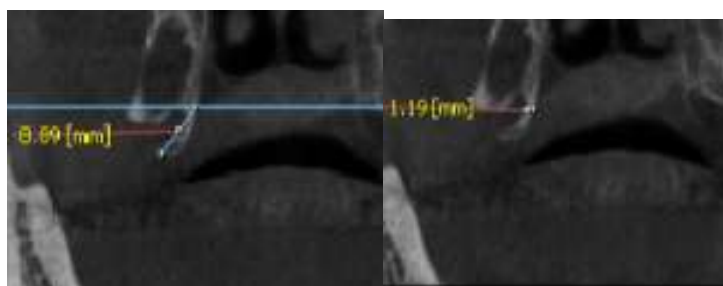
a,b, MPR CBCT images show measuring a, length and b, width of PH in the coronal plane
